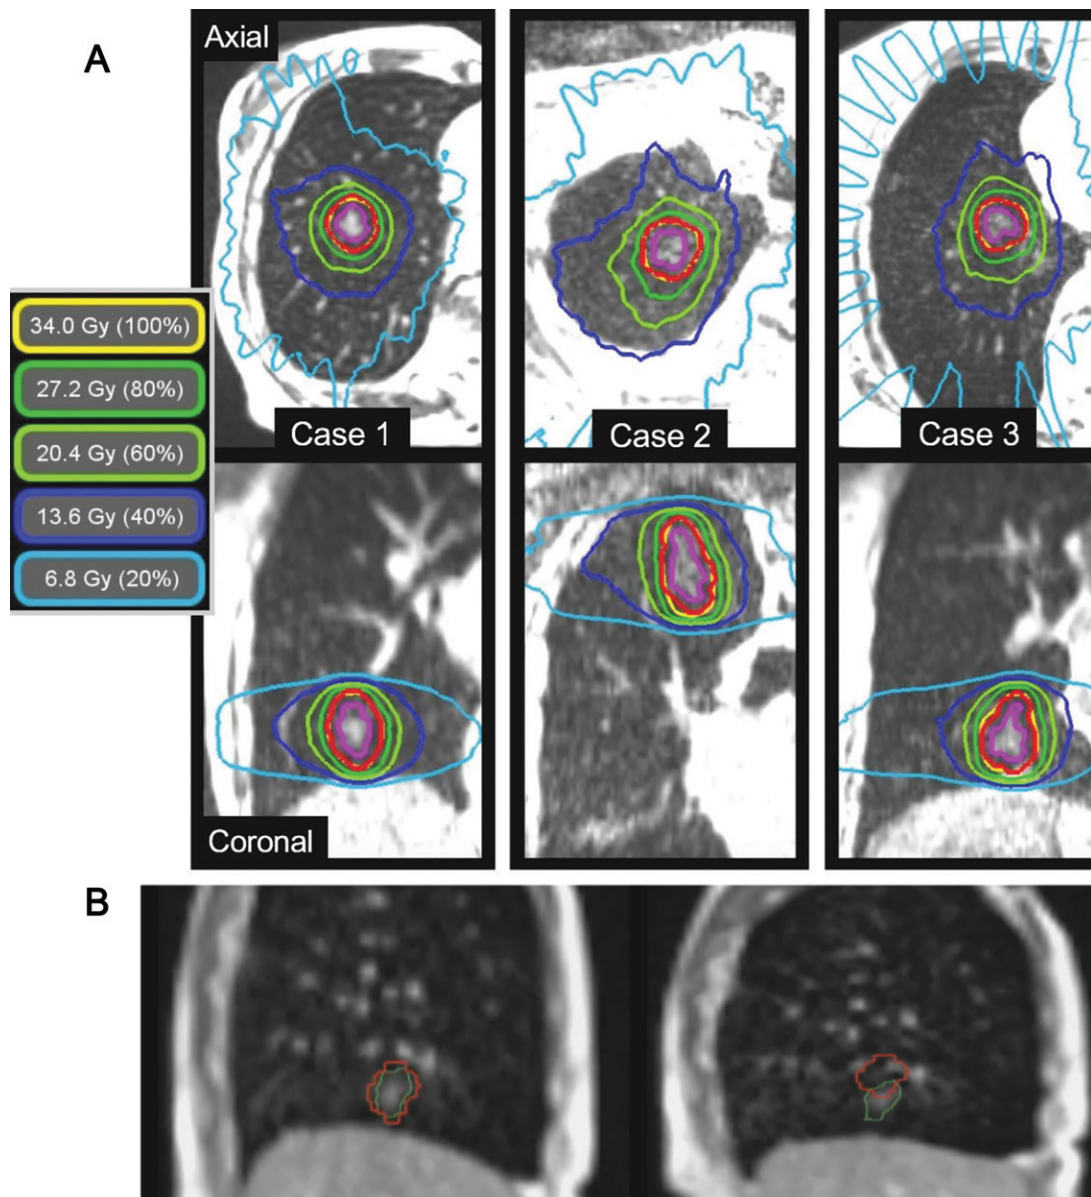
Single-fraction motion-gated lung stereotactic ablative radiation therapy by using the ViewRay 0.35-T MRI-guided linear accelerator system. A, Treatment plan for the first three patients, where one fraction of 34 Gy is delivered to the planning target volume (red). The planning target volume is created by adding a 5-mm isotropic margin to the breath-hold gross tumor volume (purple). B, Real-time two-dimensional motion tracking of the gross tumor volume (green) in one of the patients, which is performed by using two-dimensional images acquired in sagittal orientation every 250 msec and deformable image registration. During delivery, the beam is automatically turned off when a specified proportion of the gross tumor volume is outside the gating window (red). In B, on the left-hand image the full gross tumor volume is contained within the gating window, whereas on the right-hand image, about 75% of the gross tumor volume is outside the gating window. Modified, with permission, from reference 30.
